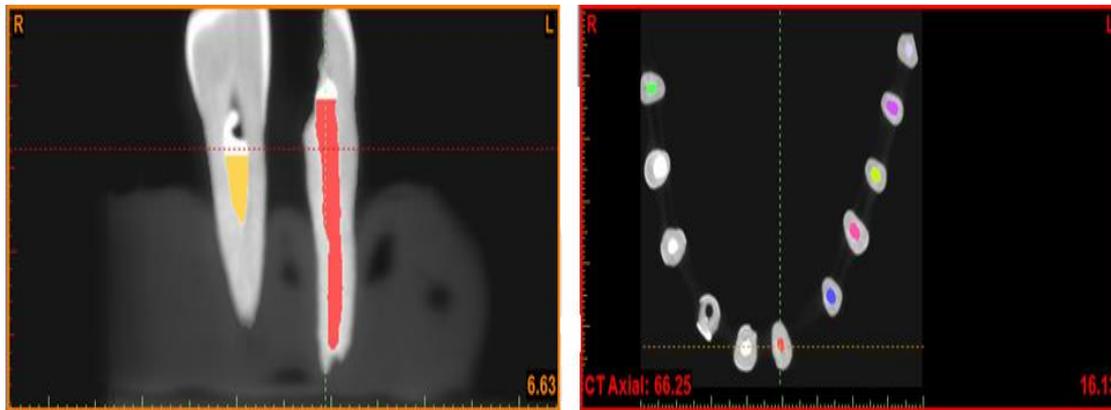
Axial and sagittal cross sections of CBCT
